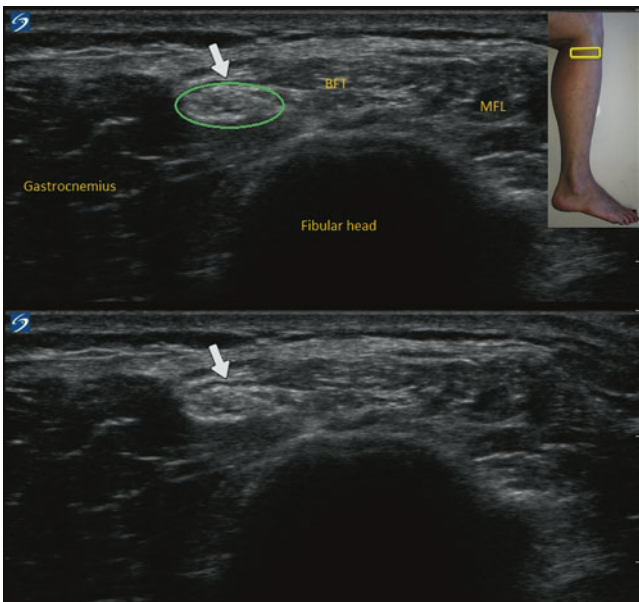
Ultrasound identification of the common peroneal nerve at the fibular head. *MFL* musculus fibularis longus (peroneus longus muscle), *BFT* biceps femoris tendon. *Arrow* points to the common peroneal nerve (Image courtesy of Agnes Stogicza, MD)
